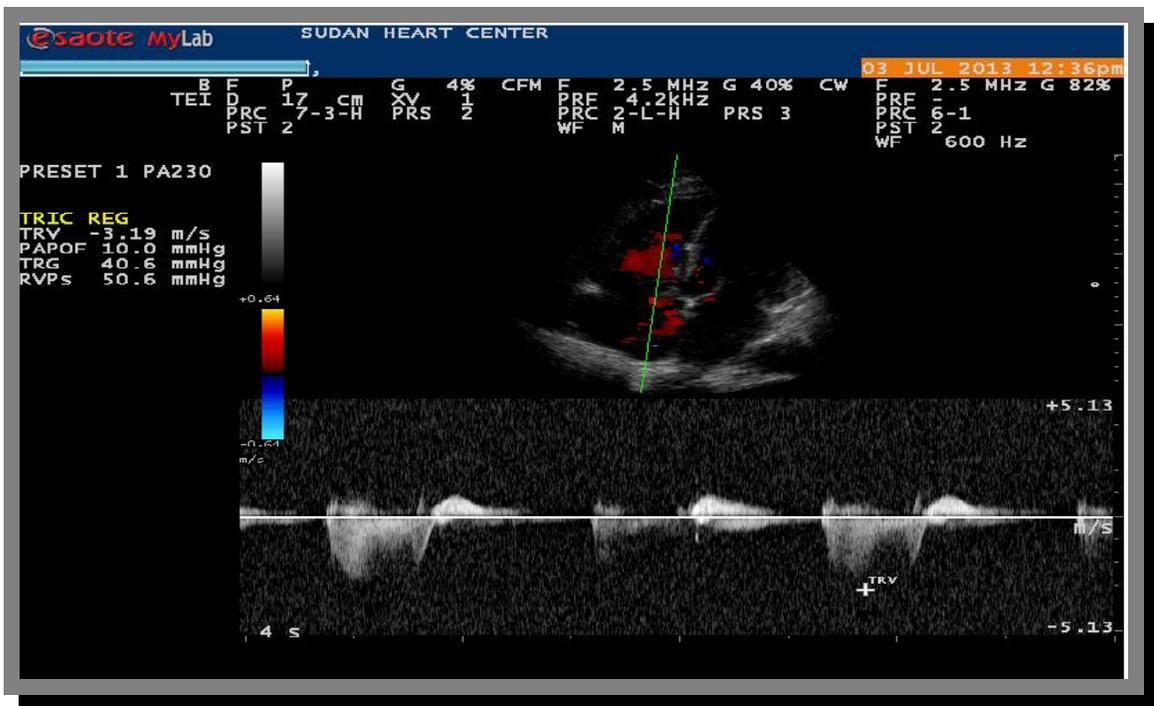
Continuous wave Doppler signal of tricuspid with a peak velocity of approximately 3.19 m/s.
